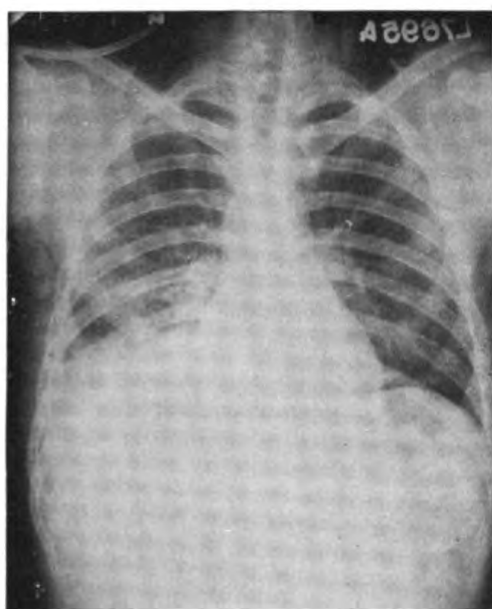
Case 5. Chest x-ray taken on admission.
